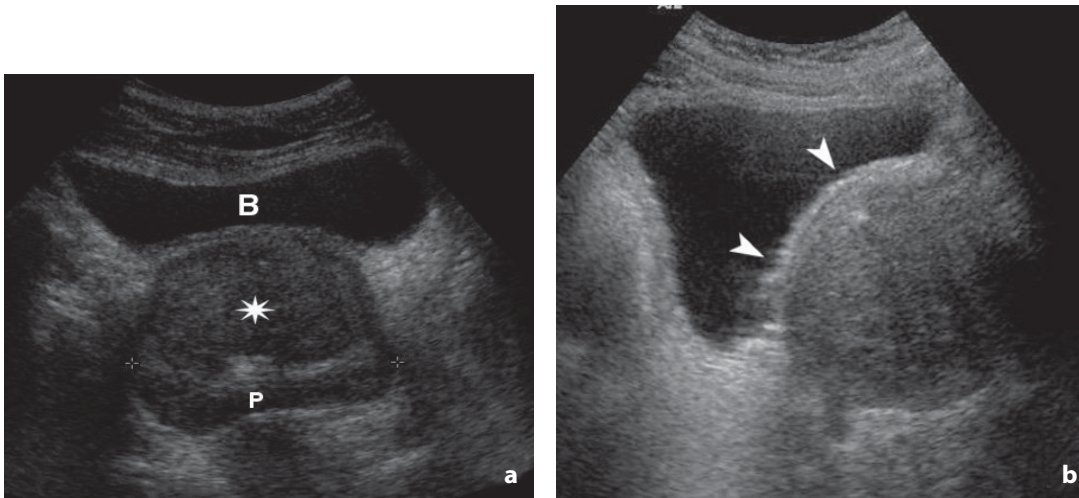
Ultrasonography. Prostate. Suprapubic approach, axial (a) and sagittal (b) scans. The prostate is clearly enlarged due to the presence of an adenoma (*asterisk*) constricting the peripheral zone (*P*). Note the impression on the fundus of the urinary bladder (*arrowheads*). *B*, urinary bladder
